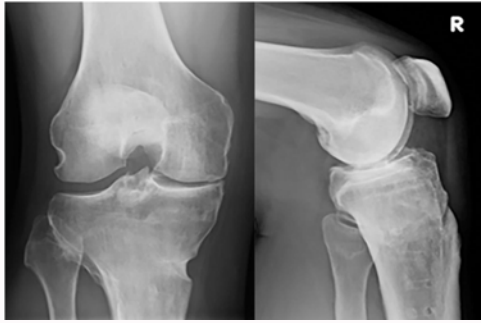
Preoperative anteroposterior and lateral radiographs of the knee showing valgus overcorrection and increased posterior tibial slope after medial open wedge high tibial osteotomy.
